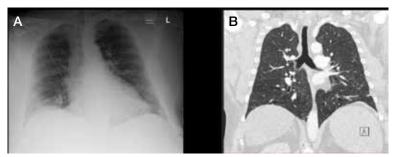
Chest anteroposterior X-ray (A) and coronal computed tomography (B) taken upon admission did not reveal any evidence of an acute cardiopulmonary process despite reported hypoxemia.
